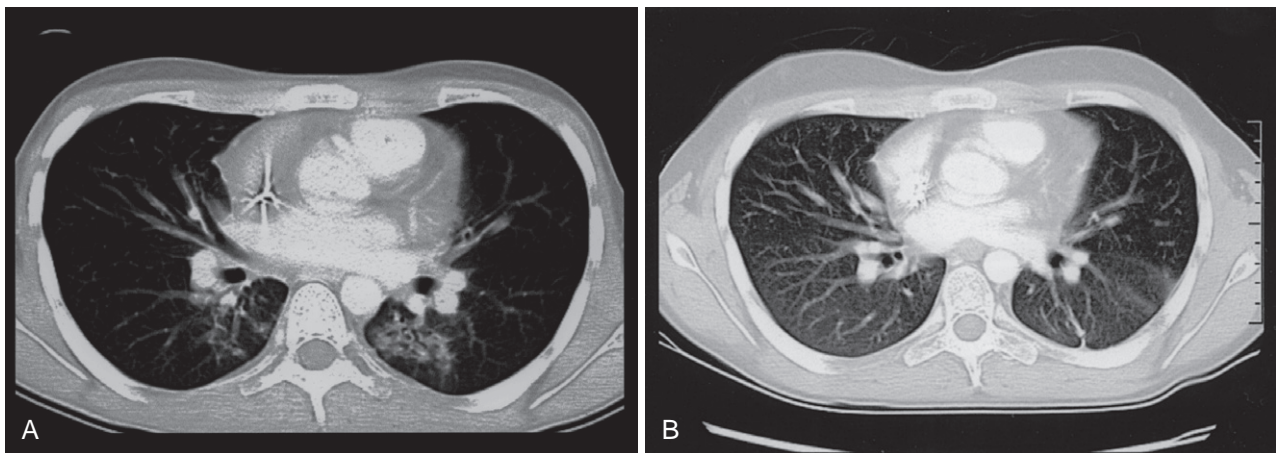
A 17-year-old child with stage IV Hodgkin disease underwent radiotherapy and autologous bone marrow transplantation. A, On routine surveillance computed tomography, bilateral focal airspace disease was seen, mostly in the superior segments of the lower lobes. Lung biopsy revealed bronchiolitis obliterans. He was treated with steroids, and a repeat scan 3 months later (B) showed a near-complete resolution.
